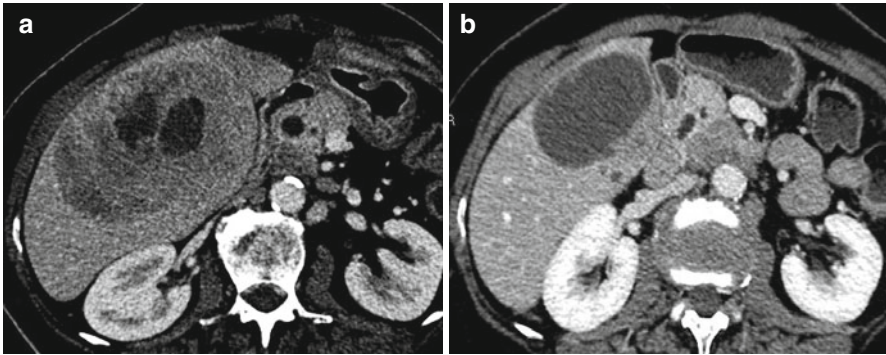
A 67-year-old woman with resected small bowel neuroendocrine tumor. (a) Axial CT scan shows big hypoattenuating liver metastases with little area of necrosis (portal venous phase). (b) Axial CT scan at the portal venous phase after bland-selective embolization of this lesion with microspheres shows a possible complete response with major necrosis and decrease in size of the lesion
